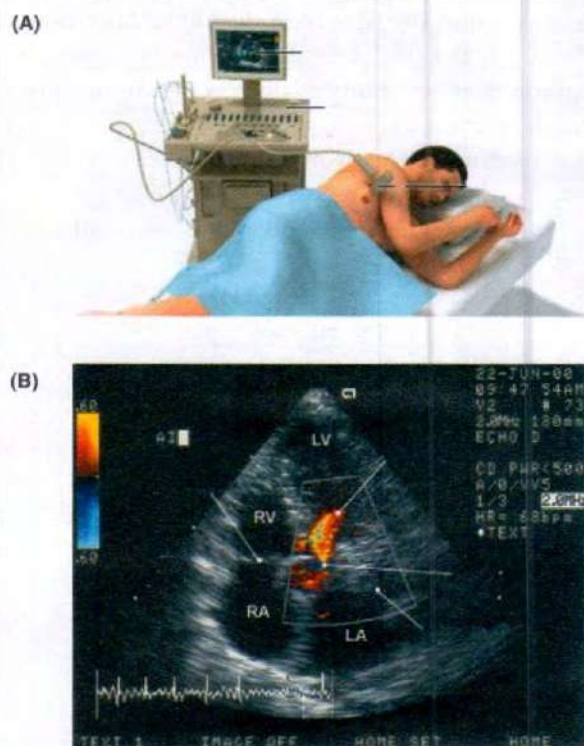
Echocardiography (A) procedure and (B) an actual record
